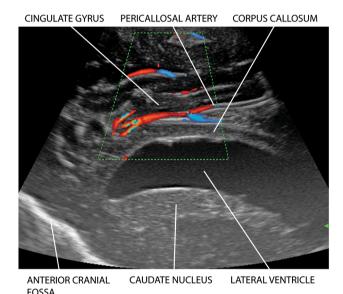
Right frontal parasagittal B-mode with Eco-color-doppler scan
